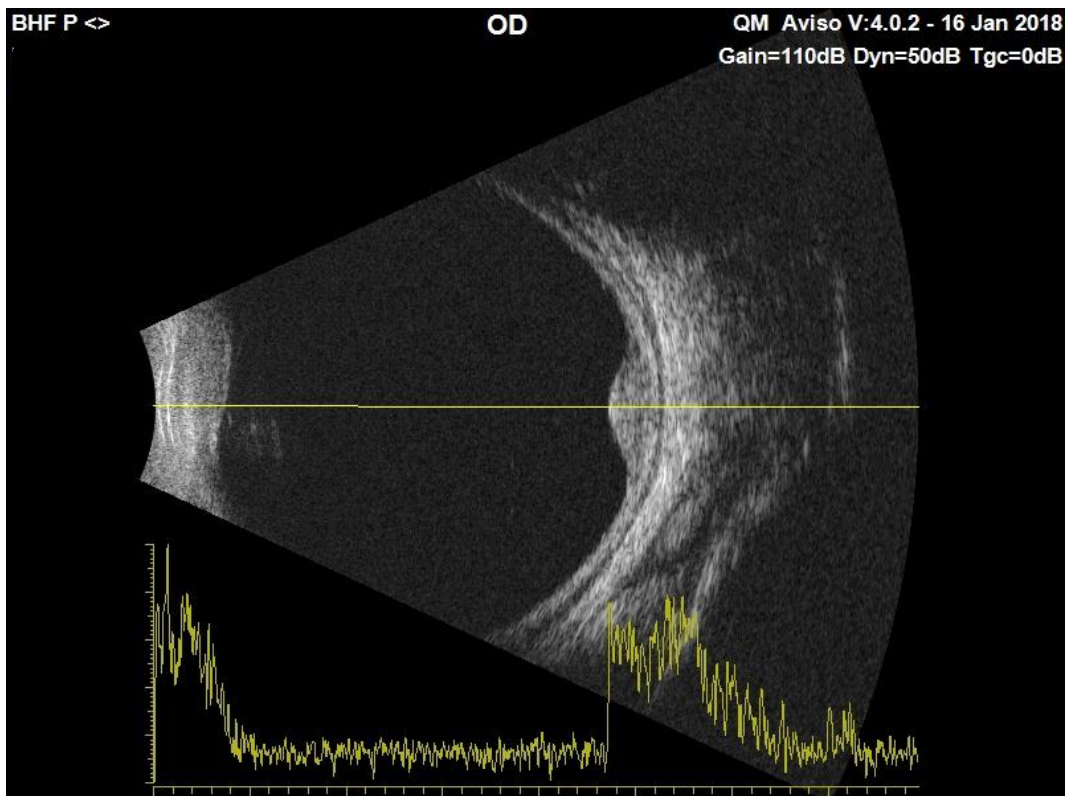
Ultrasonography (20 MHz probe) demonstrating high internal reflectivity of the lesion.
